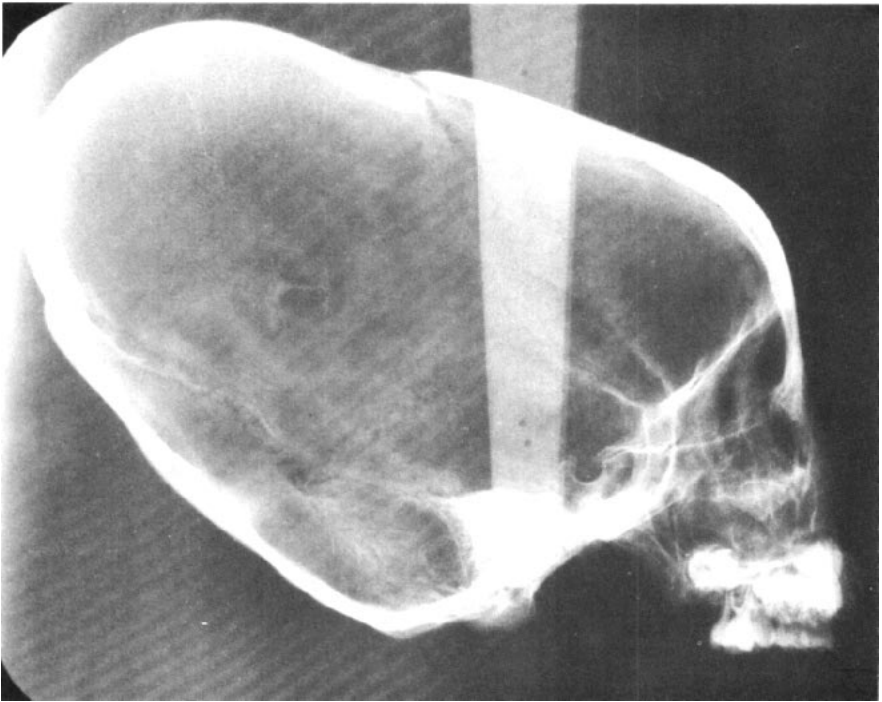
Cephalometric radiograph of human skull from Mexico which has been warped for esthetic and cultural purposes.
